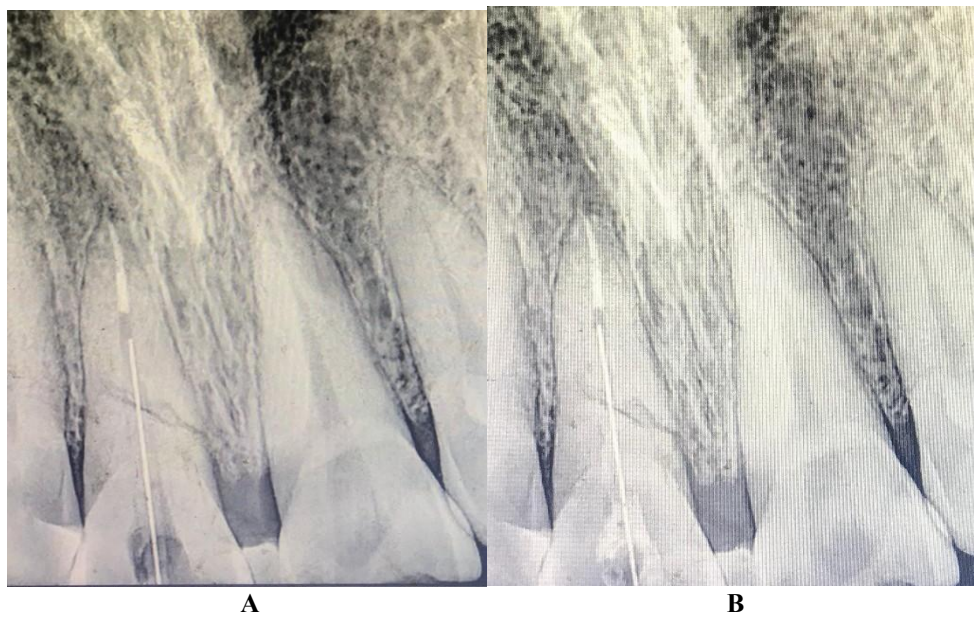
(A) Radiograph showing post space preparation and fit of the fiber post wrt tooth 11; (B) Radiograph showing fiber post cementation wrt tooth 11
